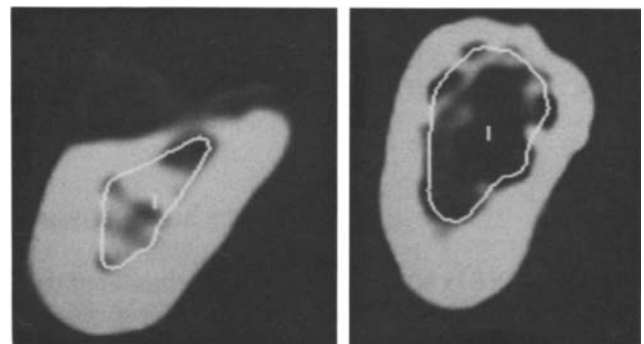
CT images from a site in the mandible where BMD was high (left) and low (right)
